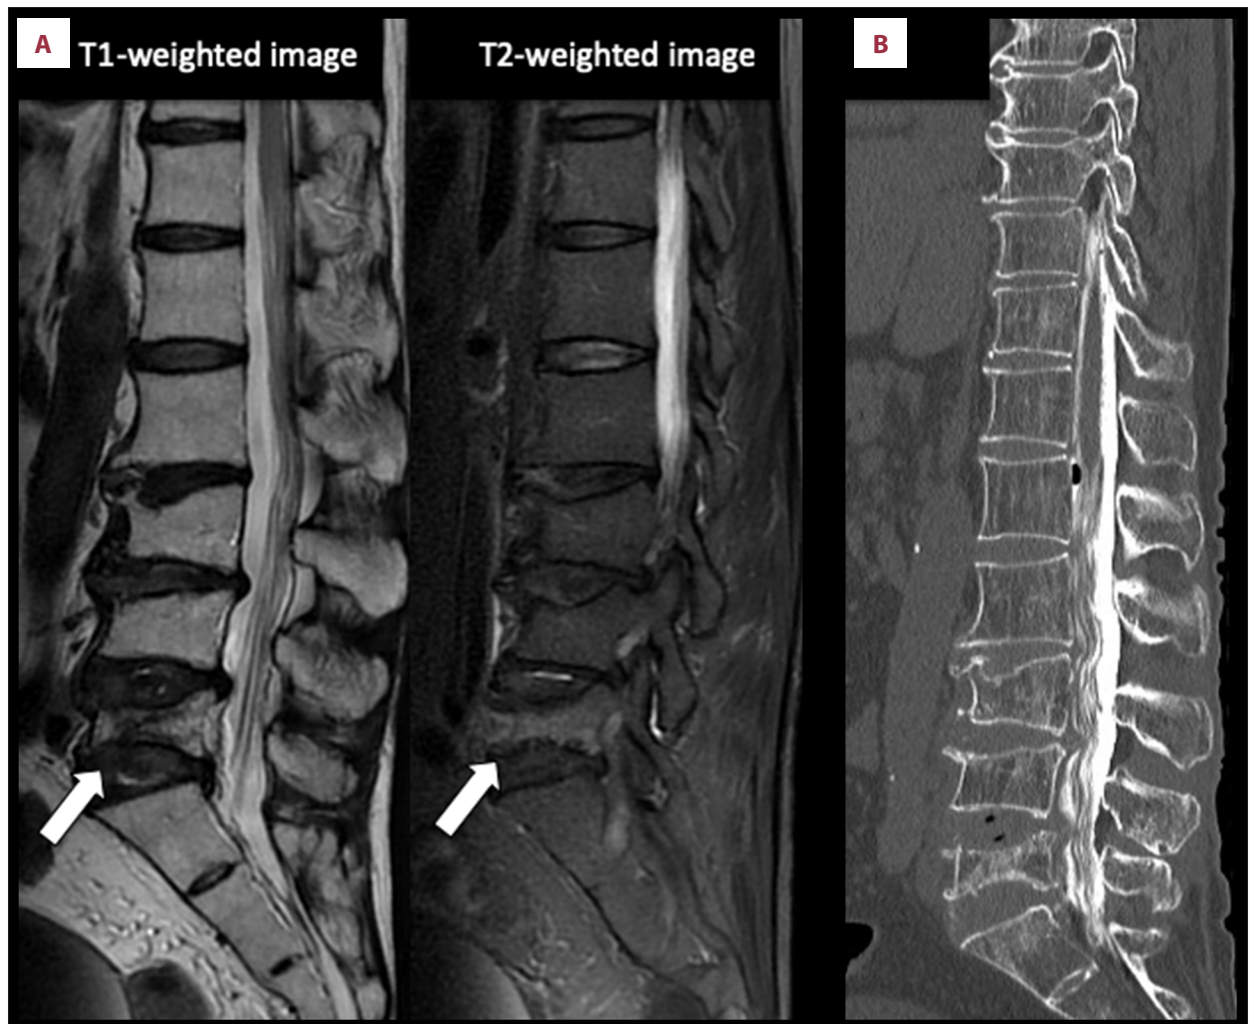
(A) Sagittal lumbar magnetic resonance image displaying a fracture with associated edema on L5. The arrow indicates the fracture. (B) Sagittal computed tomography myelography did not show compressive lesions pressing against the nerve roots and spinal cord.
